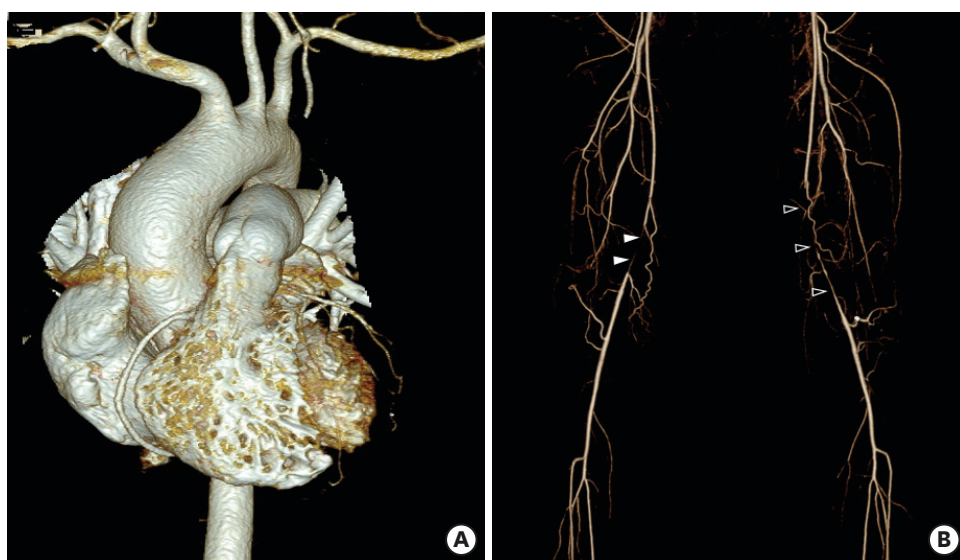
In a 30-year-old man with Takayasu arteritis, computed tomography angiography showed normal branches of the aortic arch (A), segmental occlusion of the right superficial femoral artery (white arrowheads) and long segmental occlusion of the left superficial femoral artery (unfilled arrowheads) (B).
